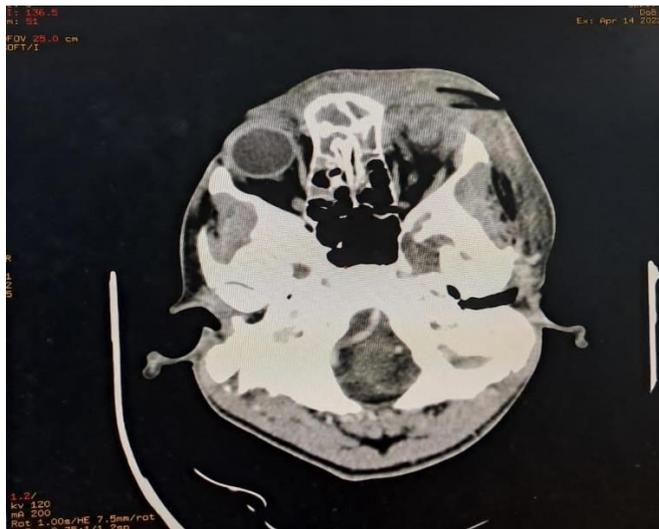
follow-up CT scan of drainage showing regression of abscess with left exophthalmos stage I+ pansinusitis. Infiltration of the upper and lower palpebral soft tissues.
